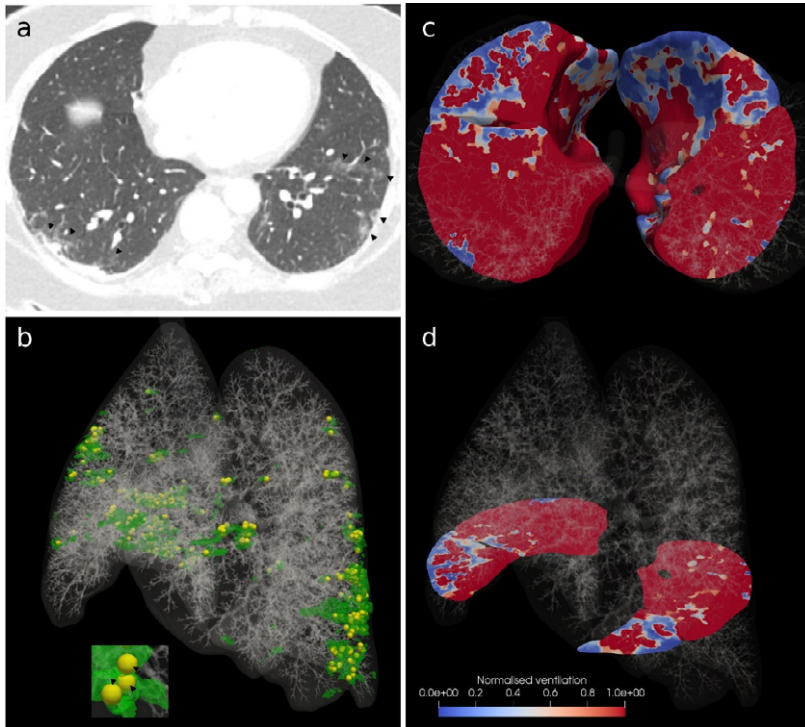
(a) CT images and (b-d) pulmonary ventilation map modelled with a full-scale airway network (FAN) flow model in a 66-year-old female with COVID-19 having respiratory distress. (a) Chest CT shows focal consolidation in the right lower lobe and small ground-glass opacities in the left lower lobe, (b) CT-based FAN flow model geometry was paired with an AI-driven CT analysis tool, MEDIP COVID19, which labels areas of pneumonia while these areas of pneumonia are marked with yellow spheres in the FAN model. (c, d) Ventilation distribution map computed with the FAN flow model shows a number of regional ventilation defects anteriorly (blue color) where no gross parenchymal lesions existed (not visible) at routine CTA.
